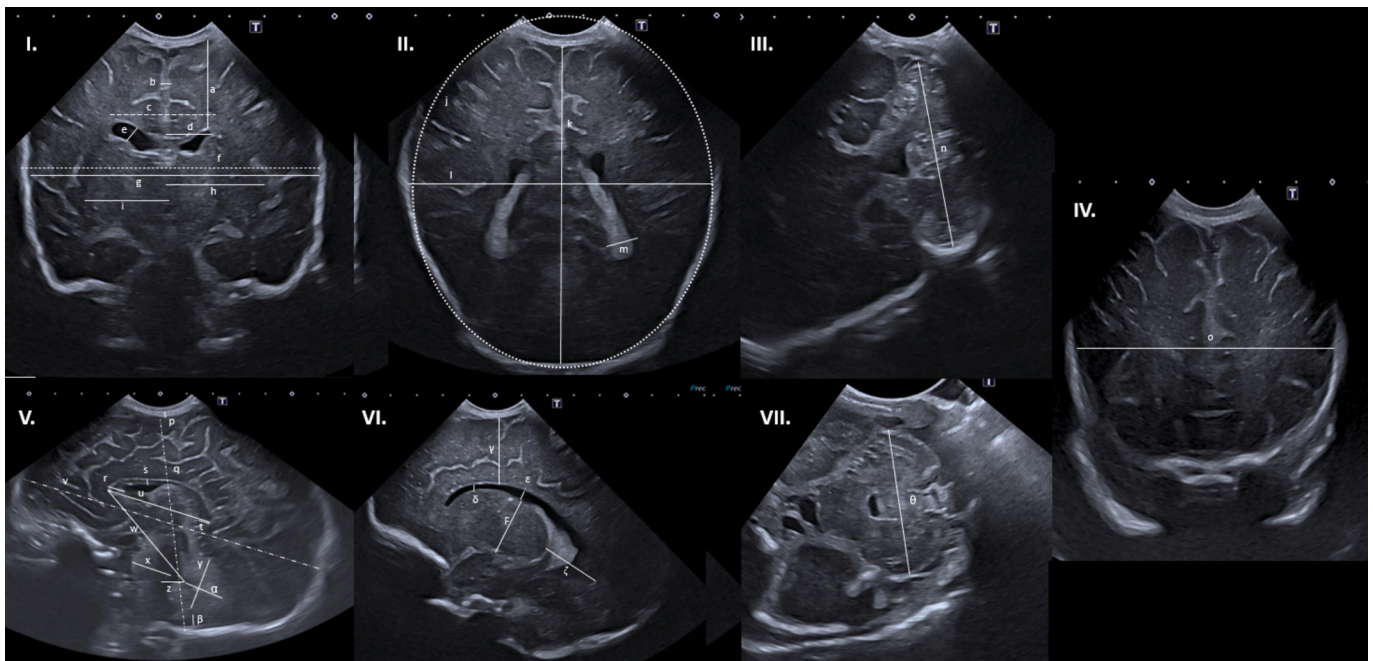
Overview of postnatal ultrasound measurements of the brain.
